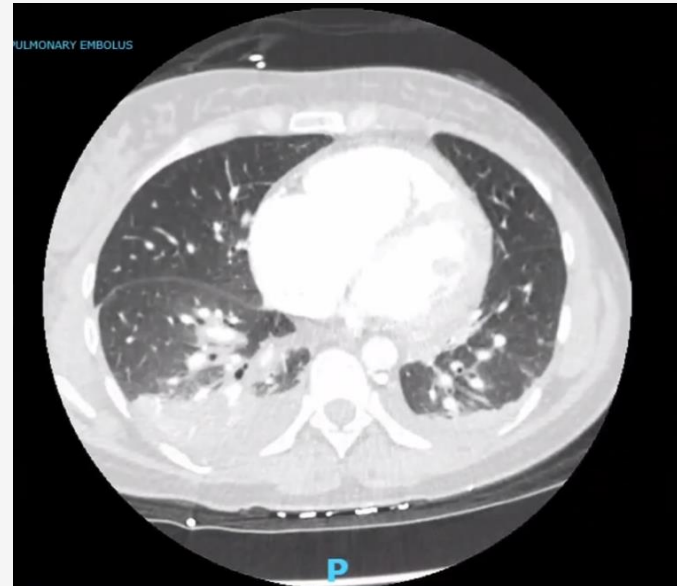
CT Pulmonary Embolus with right heart enlargement
